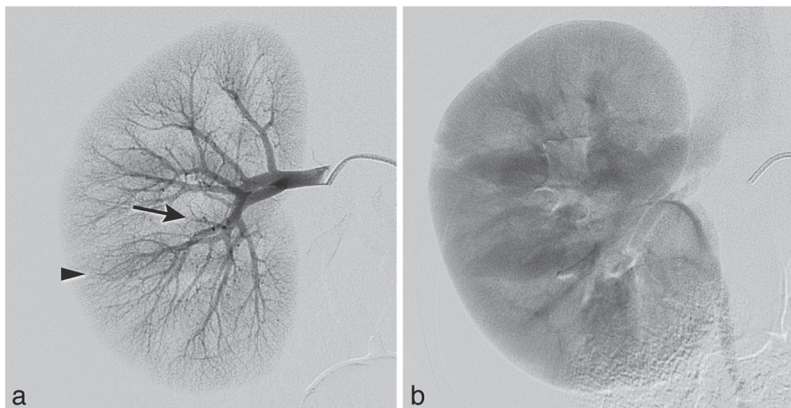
Classic angiography of the kidneys. A: both arrows indicate cut-off signs of kidney arteries. B: Cortical defects in the right kidney cortex in accordance with the MRI/MRA.
